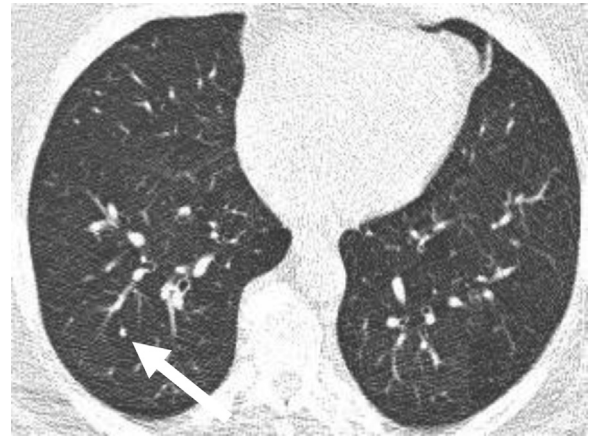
Incidental nodule requiring no surveillance. Axial computed tomography (CT) of the lung demonstrates a 3-mm nodule (arrow) in a 56-year-old woman without a history of cancer. This is a benign nodule. Follow-up CT (not shown) was performed 1 year later for another reason and demonstrated no growth in the nodule.
